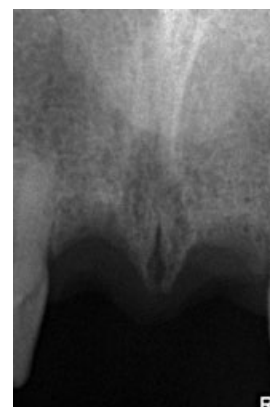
Intra-oral radiograph, note the preservation of the inter dental bone spike 11/21.
